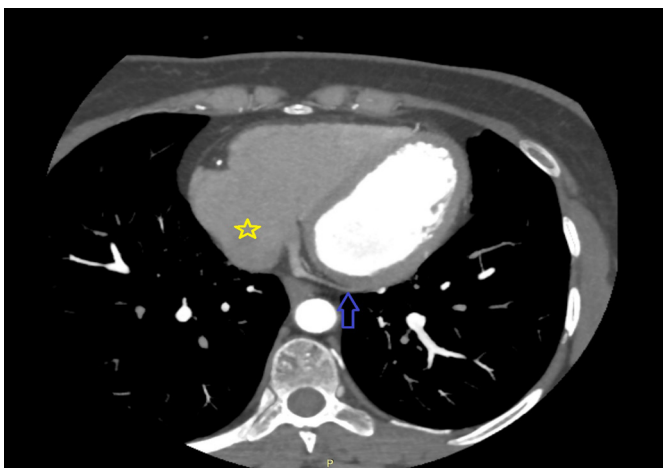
Case 1. Axial CT image, consecutive section following Figure 5. Blue arrow: coronary sinus; yellow star: right atrium
